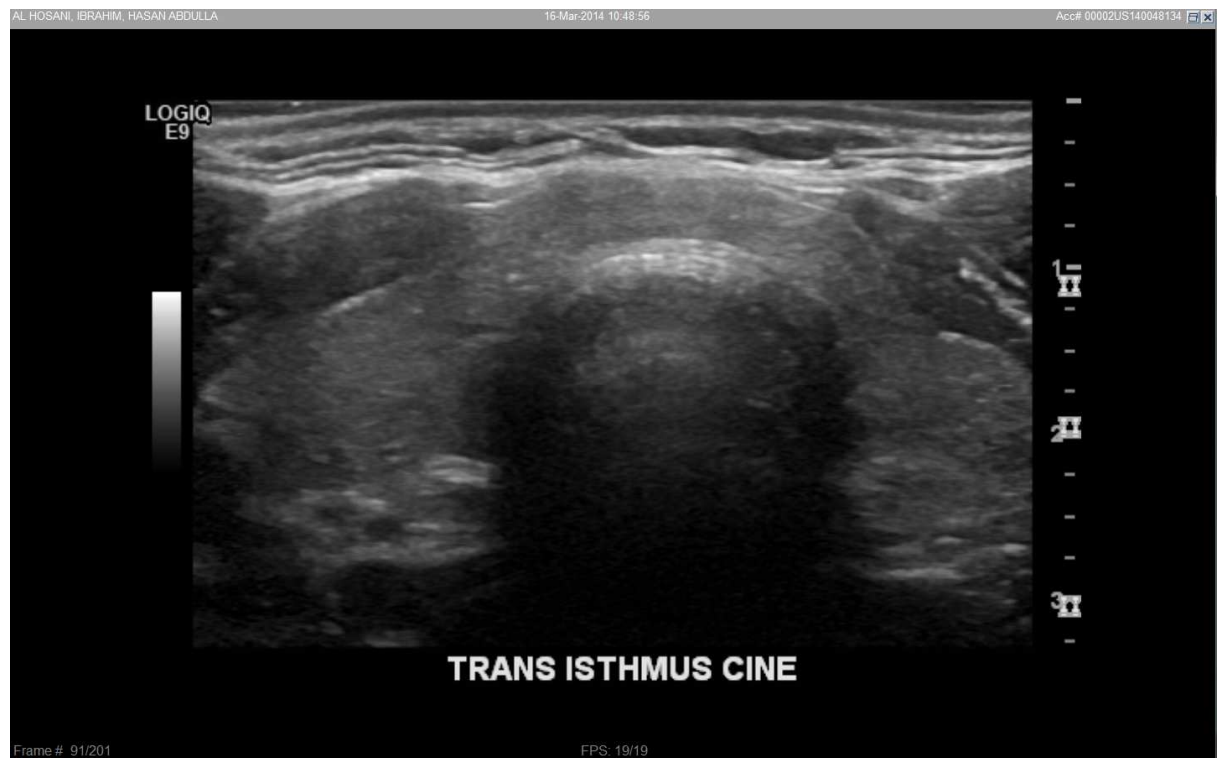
Figure A-1 ultrasound image shows thyroid and parathyroid
